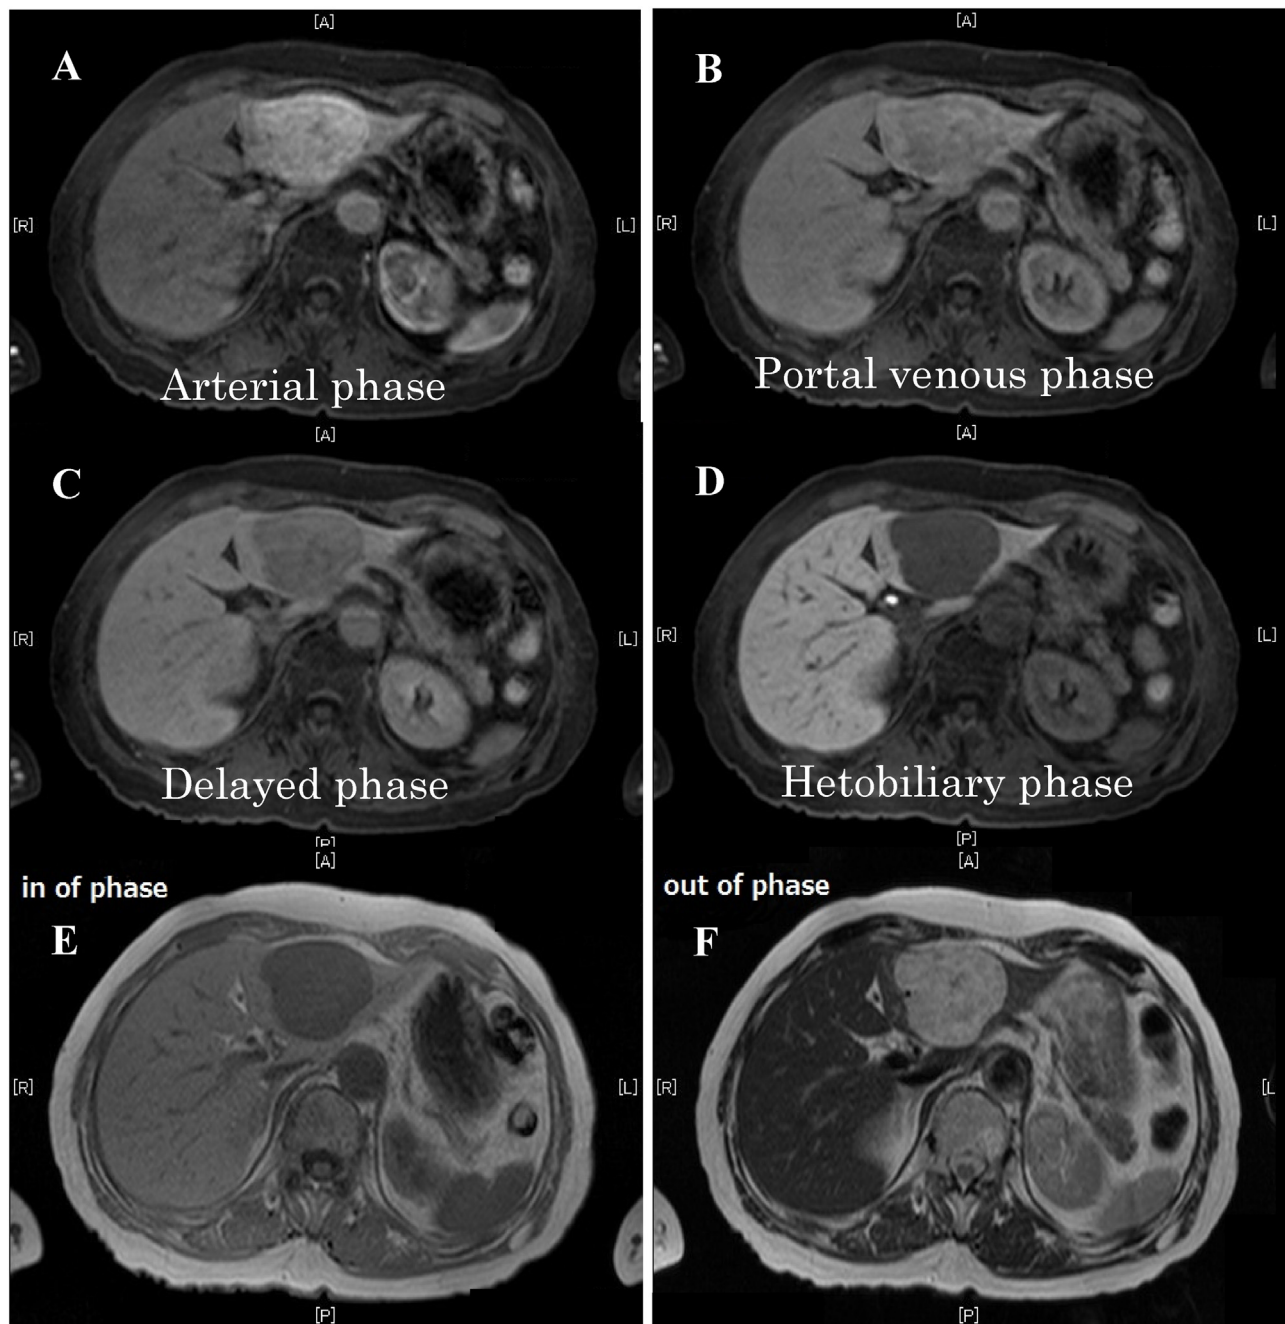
EOB-MRI showed a hepatic mass with early-phase hyperattenuation and portal-phase hypoattenuation with gradually wash out the medium (Fig. 1A and B). This was followed by a decreasing the tumour signal in the delayed phase. The hepatobiliary phase showed a wash-out pattern and low signal, which was hypoattenuation, measuring 6.2 cm × 6.0 cm (Fig. 1C and D). The opposed phase of EOB-MRI revealed high intensity of whole the tumour with small low intensity inside the tumour.
